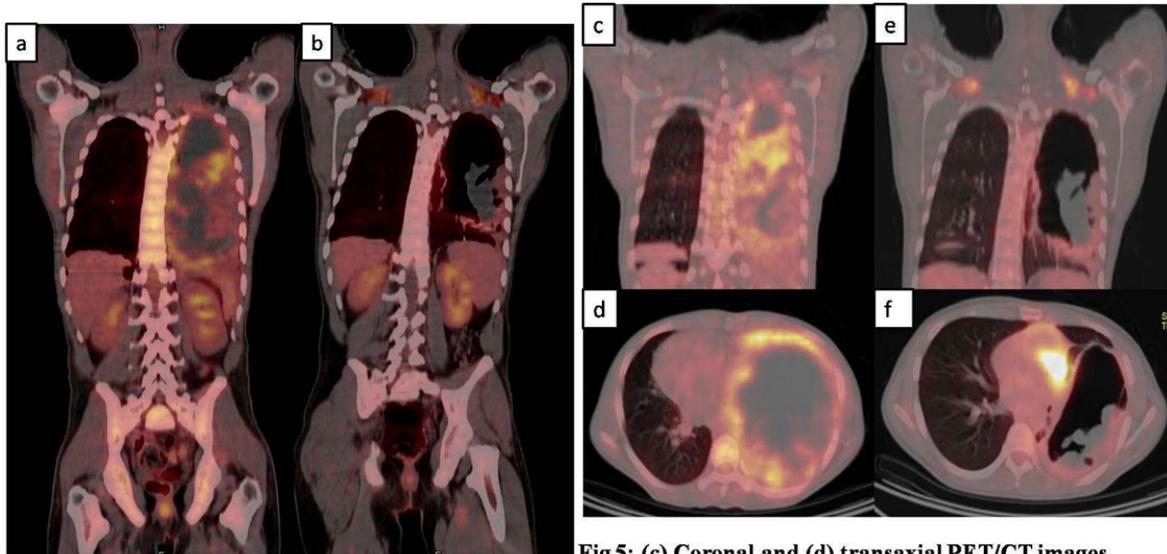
Coronal PET/CT images (a) pretherapy scan- mass lesion in left lung and (b) posttherapy showing significance response to chemotherapy and residual disease in left lung
